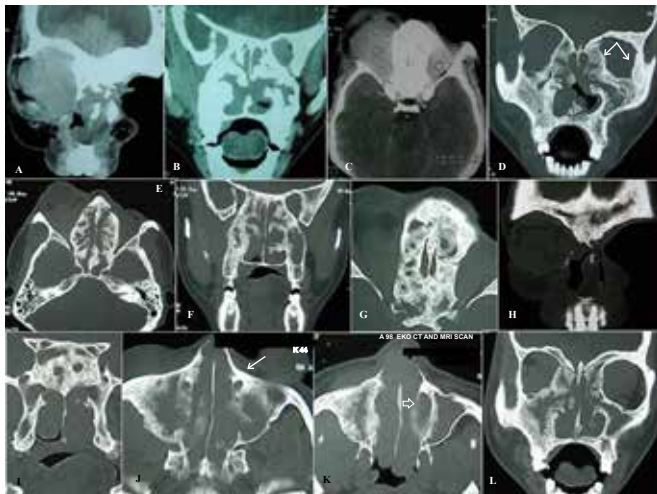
Computed tomography (CT) features of the facial skeleton (A–I: present scans; J–L: earlier scans): CT showed enhanced mass lesion in the nasal cavities, orbits (A–D) and intracranial compartment (A, B). The facial skeleton had a peculiar moth-eaten appearance with areas of sclerosis and resorption, suggesting prolonged inflammatory process. This was more prominent in the perisinus bony framework, involving maxilla (D), ethmoids (E–G), frontal (H) and sphenoids (I). Note the porous, sieve-like appearance of the cribriform plate (G)—the potential route for intracranial spread in this patient. Also note the areas of sclerosis around the left orbit (D) and nasolacrimal duct (J) (arrows). There was characteristic involvement of the left middle turbinate (K) (hollow arrow) with destruction of a large part of the septum (D). A comparison between the present and previous scans (D and L, respectively) showed a gradual decrease in the sinus spaces due to progressive bone remodelling and mass effect.
